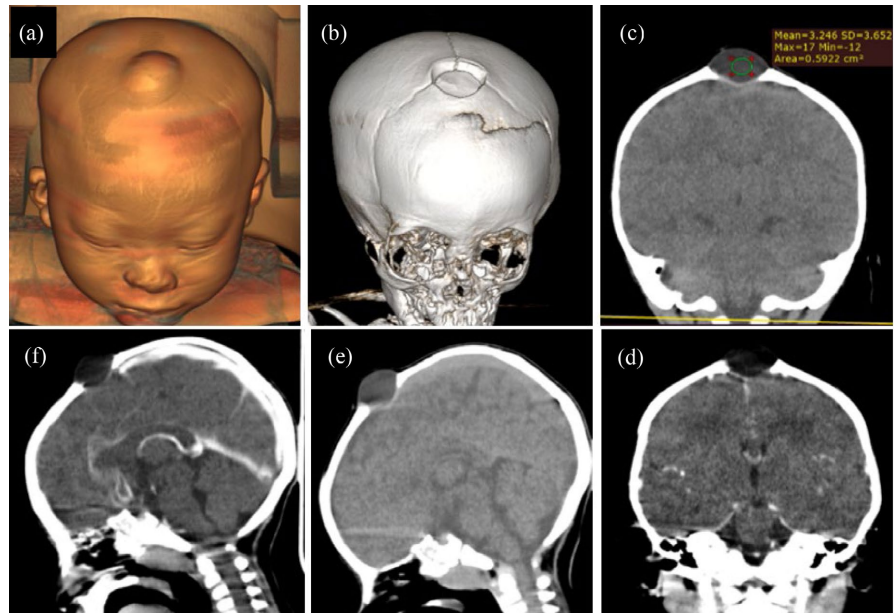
Cranioencephalic CT: scalp mass over the anterior fontanelle with a cranial depression at the bregma on 3D reconstructions (a) and (b); extracranial midline fluid-density mass without contrast enhancement on coronal reconstructions before and after contrast injection (c)-(f).
